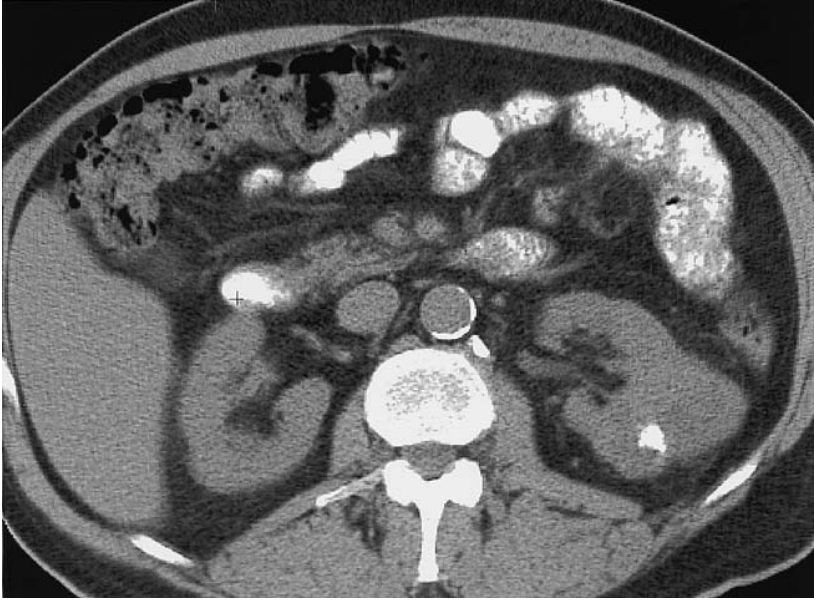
Unenhanced axial CT image obtained at 70 mA for CTC demonstrates an 5 cm exophytic left renal mass with calcification.
